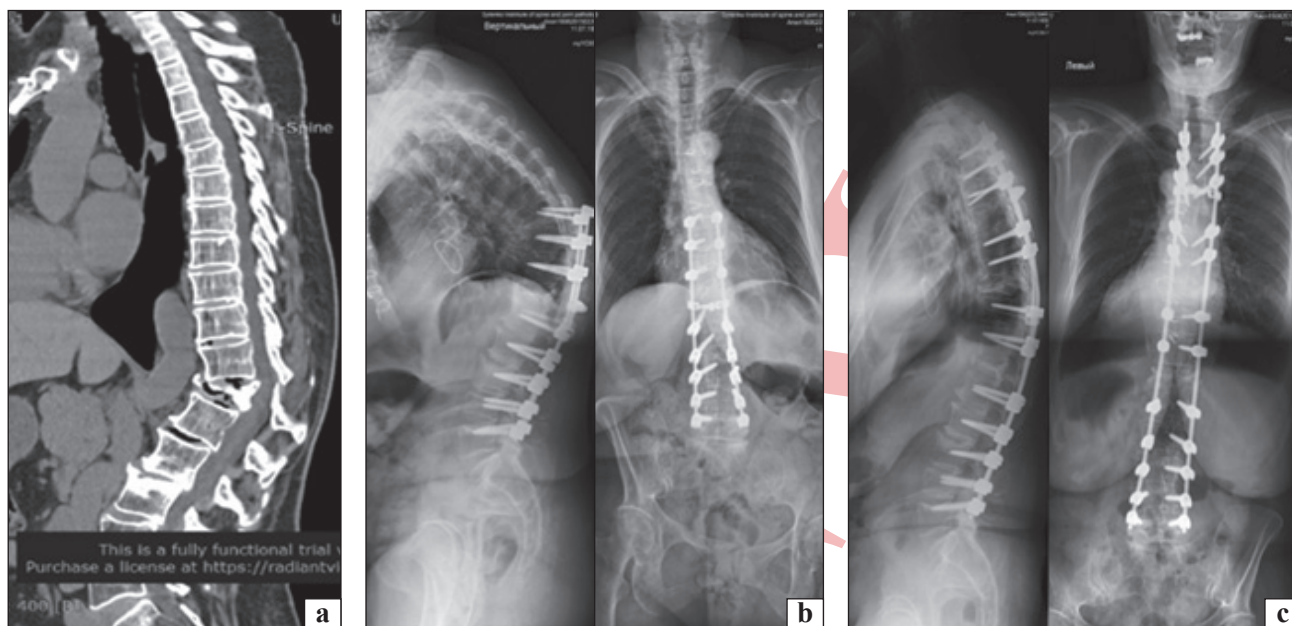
X-ray Images: a) Before surgery and b) After initial surgery. One month later, c) Revision of the transpedicular system
